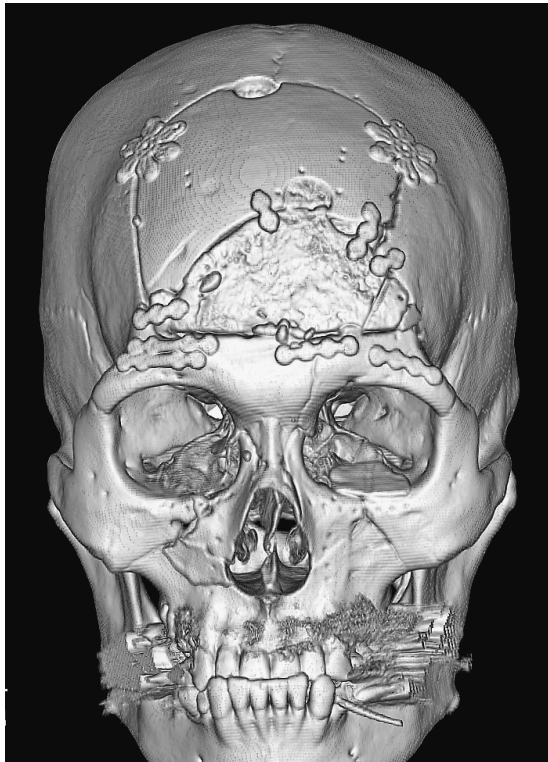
Three-dimensional computed tomography postoperative repair of the complex craniofacial fractures.
